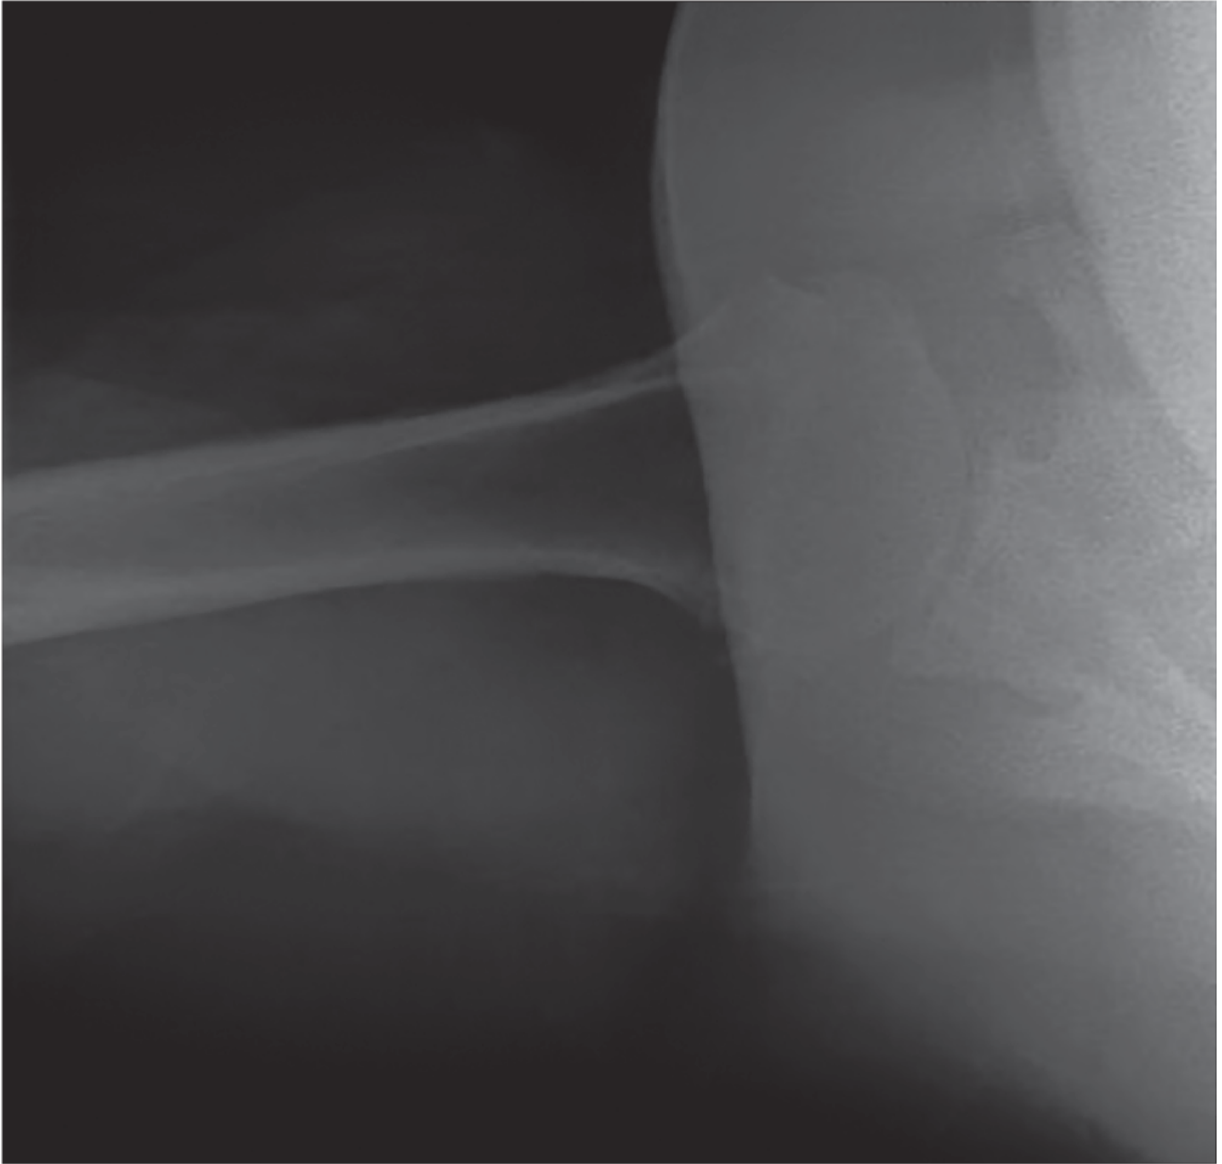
Axillary radiograph of the left shoulder showing concentric glenohumeral joint space loss without subluxation of the humeral head or any eccentric wear. Source: Chad Myeroff, Michael Knudsen, Michael D. McKee.
